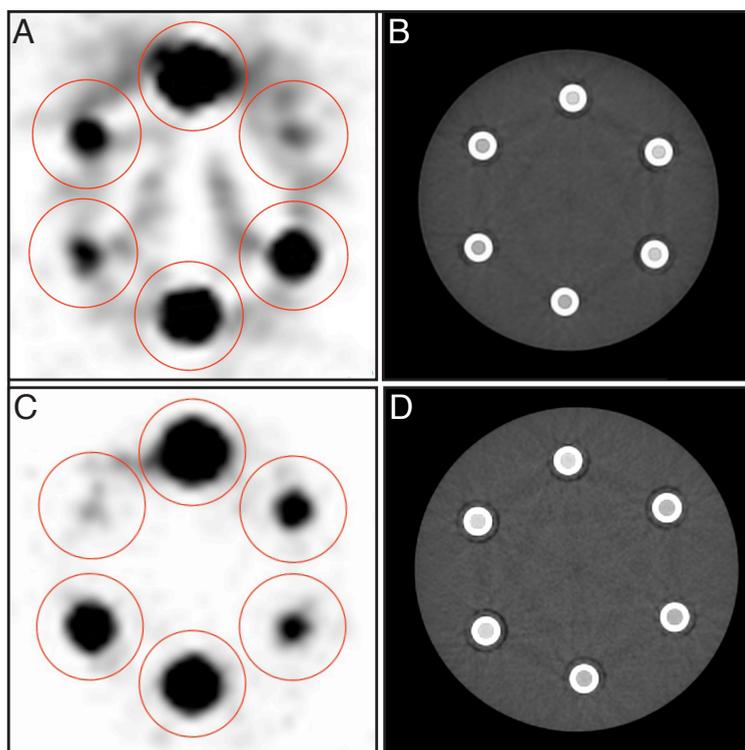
Examples of PET and CT images of axial slices acquired from scanner of vendor A (2A-B; obtained from scanner number 5) and vendor B (2C-D; obtained from scanner number 15) to emphasize the differences between the two scanner vendors. Both scanners were calibrated shortly after each other, so decay of the reference activities was negligible. At the time of calibration, the top vials contained a reference activity A_r of 2.49 MBq. Clockwise, the other vials contained 2.6, 127, 514, 13 and 26 kBq, respectively. Figures 2A and 2C: CTAC images, with circular regions of interest matching with the VOIs (in red). Figures 2B and 2D; corresponding CT images.
